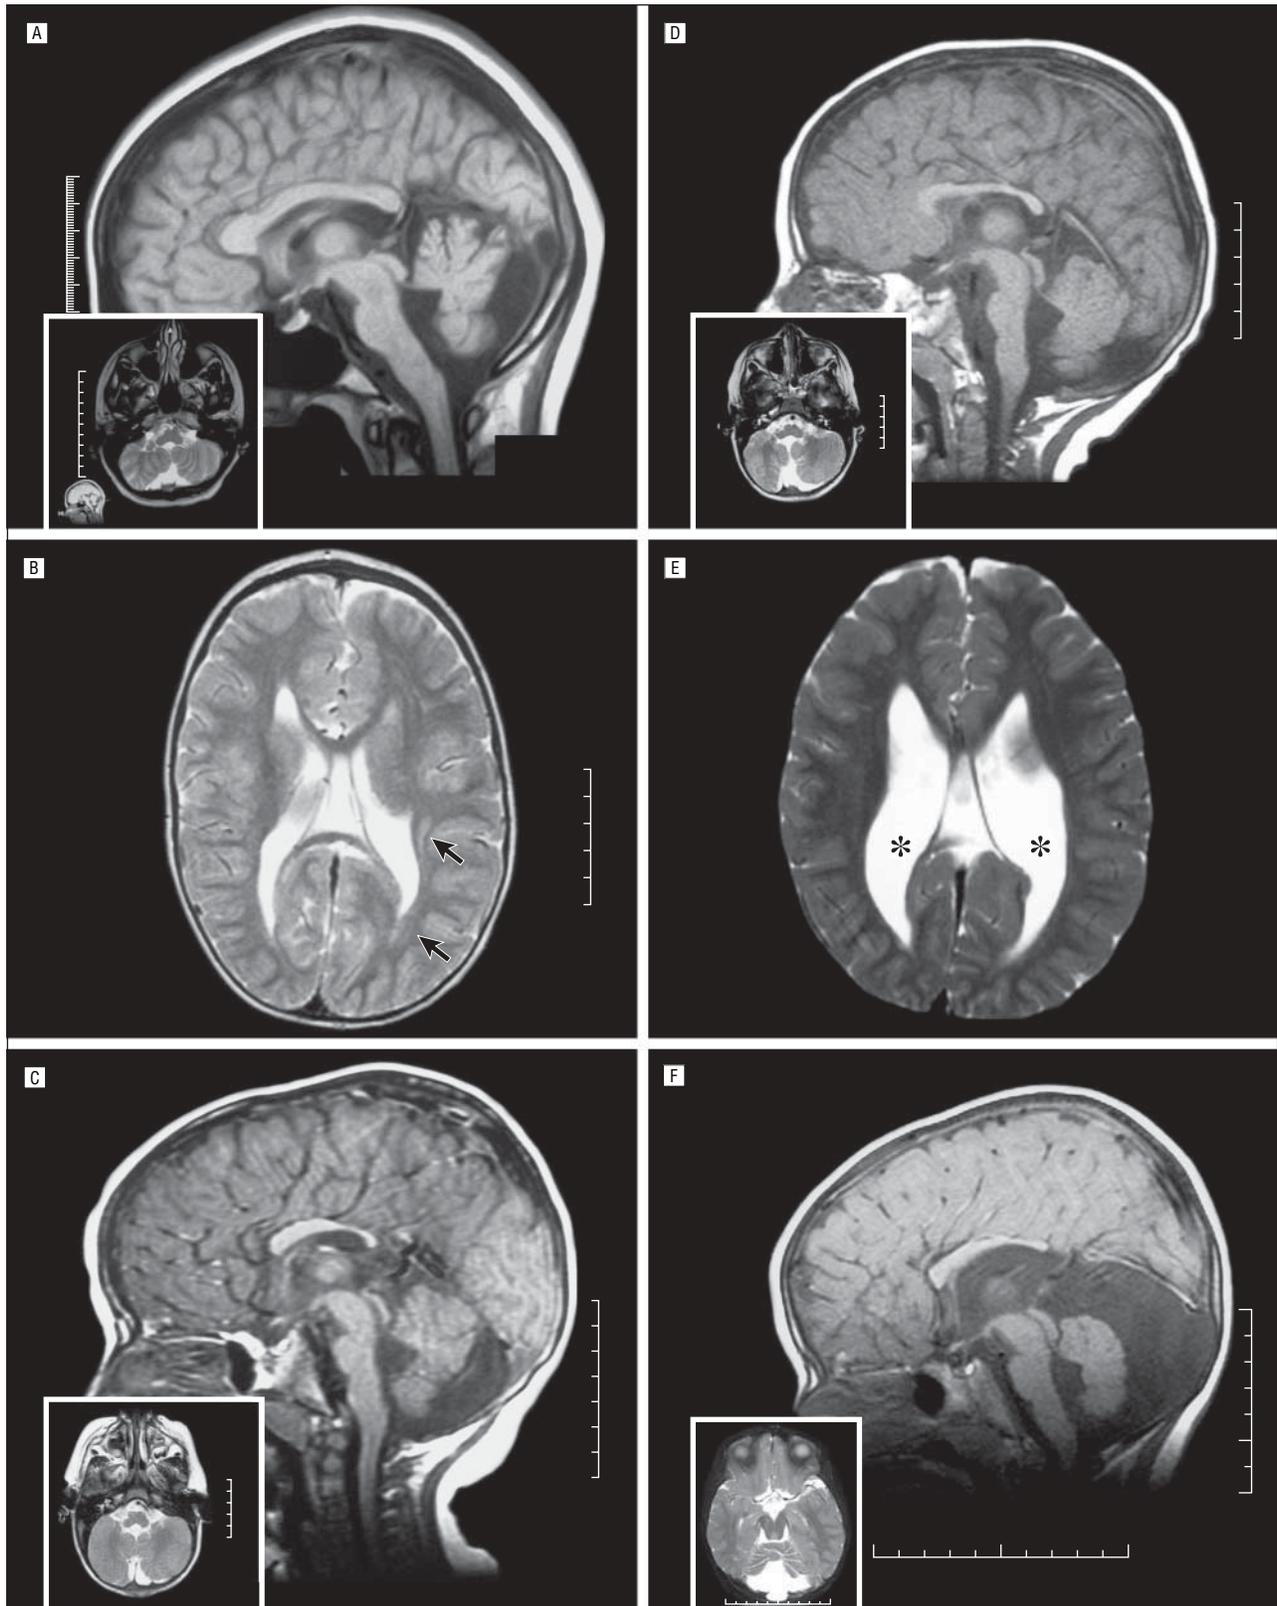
Magnetic resonance images (MRIs) of the brain of affected individuals. Insets represent axial MRIs at the level of the cerebellum and brainstem that show the uniform finding of vermian atrophy in all affected individuals. The scales are in centimeters. A, Sagittal T1-weighted MRI of the mother (II:2) demonstrates cerebellar vermian atrophy, a mega cisterna magna, and callosal thinning. B, Axial T2-weighted MRI of the oldest affected son (II:1) shows subcortical heterotopia (arrows) along the lateral ventricles. C, Sagittal T1-weighted MRI of the same individual is also notable for inferior vermian hypogenesis, a mega cisterna magna, and callosal thinning. D, Sagittal T1-weighted MRI of the middle child (II:2) is remarkable for a cerebellar vermian hypoplasia, decreased white matter volume, and a mega cisterna magna. E, Axial T2-weighted MRI of the youngest child, a girl (II:3), demonstrates mild ventriculomegaly (asterisks). F, Sagittal T1-weighted MRI of the same individual reveals hypoplasia of the cerebellar vermis, a mega cisterna magna, and dysgenesis of the posterior aspect of the corpus callosum.
